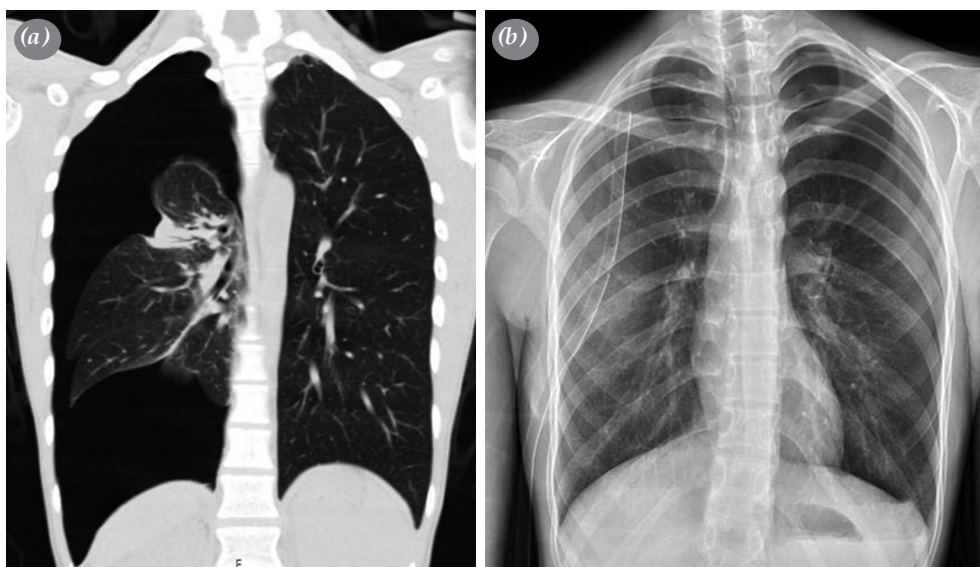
(a) Coronal view of computed tomography showing the total lung collapse of left lung and apical bleb in right lung. (b) Chest X-ray showing the thorax drain in right lung and partial lung collapse in left lung four days after chest tube insertion to right lung.
